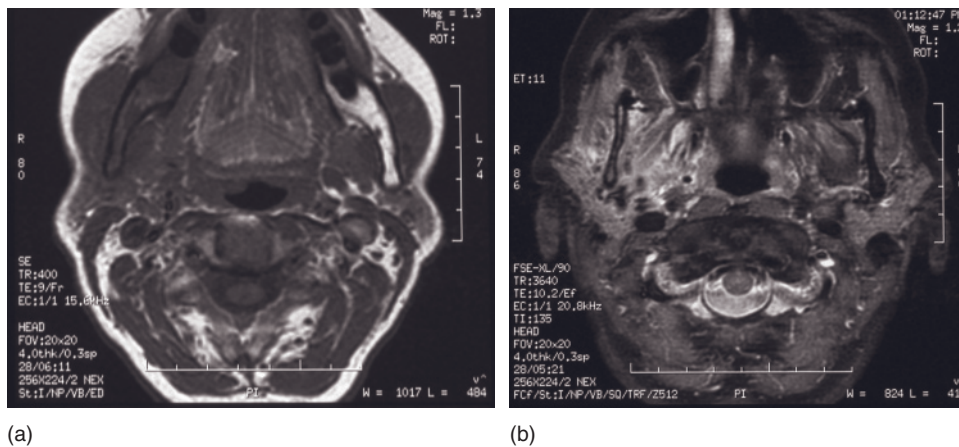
(a) A T1-weighted image showing low signal in bone in the right ramus, due to the presence of inflammation, compared with the high signal from the fatty marrow on the normal left side. (b) A T2-weighted image at a slightly higher level showing a high signal in the bone and surrounding soft tissues of the masticator space on the right side due to the presence of inflammation.
